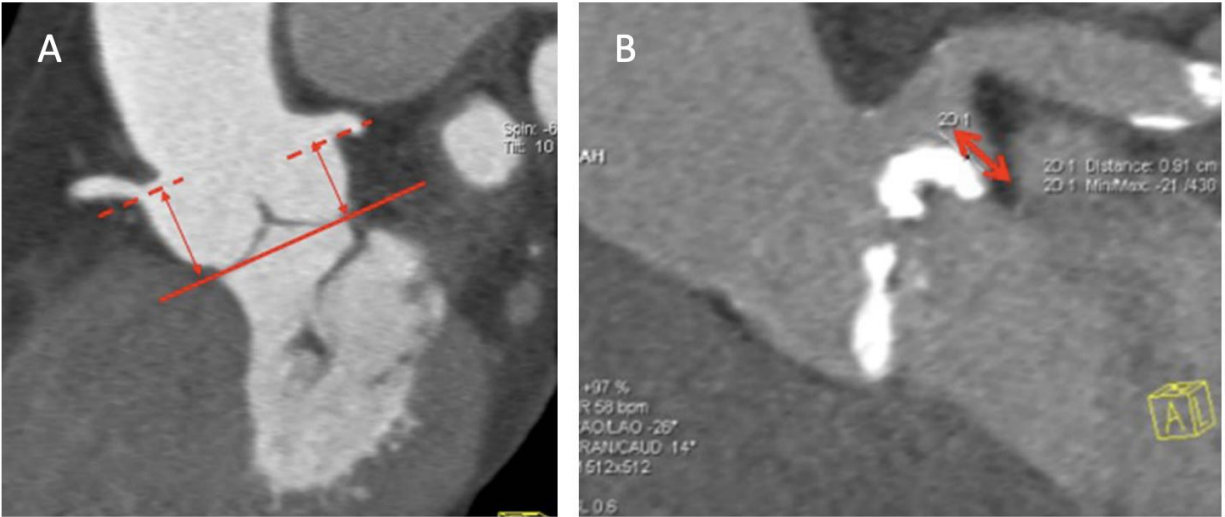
A) Measurement of the distance between the coronary ostia and the aortic annulus plane. B) Severely calcified left coronary cusp with close relationship between annular plane and ostium of the left main coronary artery (red arrow). (Reused with permission from Springer Nature publishing. Mohamed Marwan et al, Role of Cardiac CT Before Transcatheter Aortic Valve Implantation (TAVI). *Curr Cardiol Rep.* 2016 Feb;18(2):21. doi: 10.1007/s11886-015-0696-3)⁴³.
